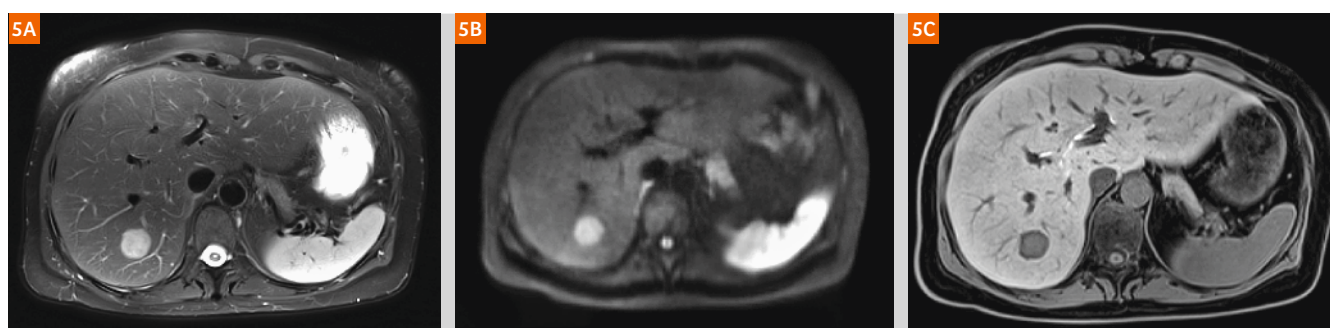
38-year-old patient with hepatic adenoma. (5A) T2-weighted fast BLADE sequence: A hyperintense 2 cm sized mass in the Couinaud-segment VII. The acquisition with optimized radial spokes makes the sequence robust against respiratory motion and reduces typical star and hook artifacts. Furthermore, phase-encoding artifacts caused, for example, by pulsation, do not occur due to the radial acquisition. (5B) Diffusion-weighted sequence with b-value 800 s/mm² with SliceAdjust: The lesion shows diffusion restriction. The strong 60/200 XT gradients provide high signal even at high b-values. Slice selective shimming with SliceAdjust reduces distortion artifacts. (5C) Dixon-VIBE sequence with PAT6: The lesion shows some uptake of the hepatocyte specific contrast agent Eovist (Bayer, Berlin, Germany). High acceleration factors are possible with the combination of the 72-channel Spine coil and the 30-channel Body coil. Breath-hold duration is only 8 seconds, still delivering high image quality.
